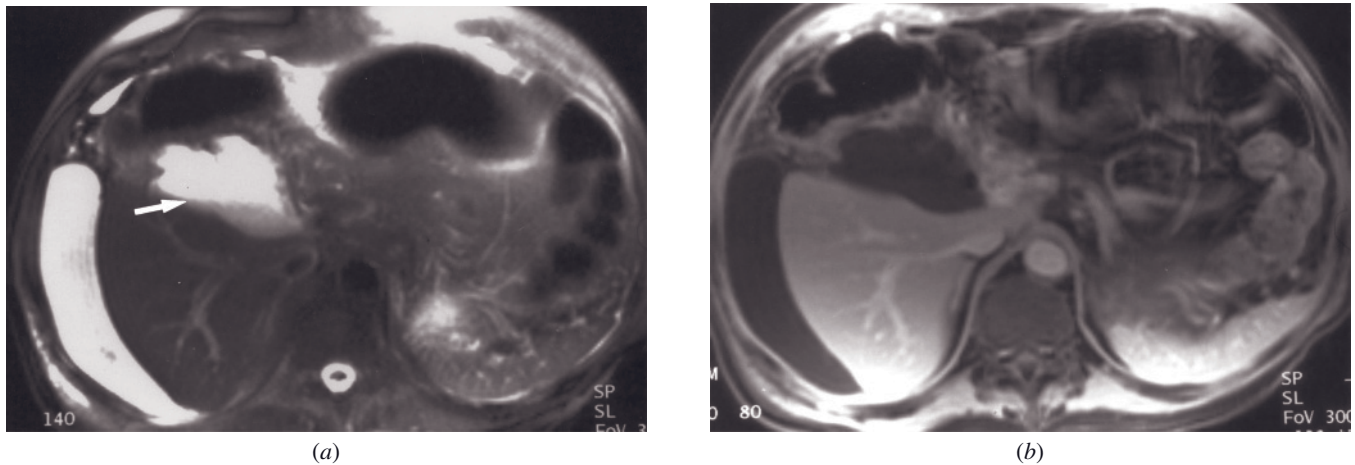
Infected biloma. T2-weighted fat-suppressed SS-ETSE (a) and 90-s postgadolinium fat-suppressed SGE (b) images. There is a fluid collection in the region of the gallbladder fossa that appears somewhat loculated and complex, as evidenced by a fluid-debris level (arrow, a) on the T2-weighted image. Note that debris has an irregular linear interface with fluid, unlike high-protein-content ascites, which has a sharp linear fluid-fluid level. A moderate amount of perihepatic ascites is also present, associated with increased peritoneal enhancement. The patient had a recent history of cholecystectomy, and these findings are consistent with infected biloma with peritonitis.
